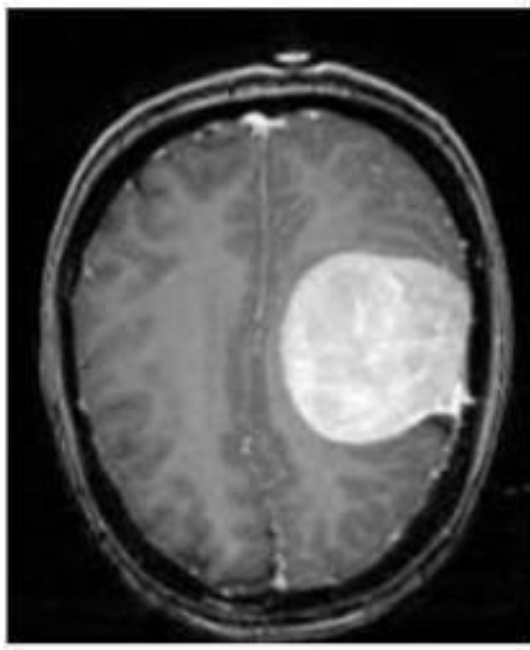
Input brain MRI image from the dataset used for the CNN model.
